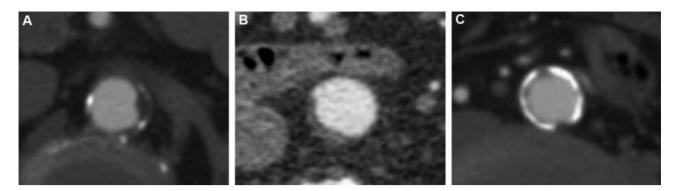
Representative computed tomographic images of selection criteria. (A) Thickness of the thrombosis is >3 mm in the aorta or iliac artery; (B) thrombosis is more than one-third of total circumference of the aorta or iliac artery; (C) calcification present in the entire circumference of the aorta or iliac artery.
